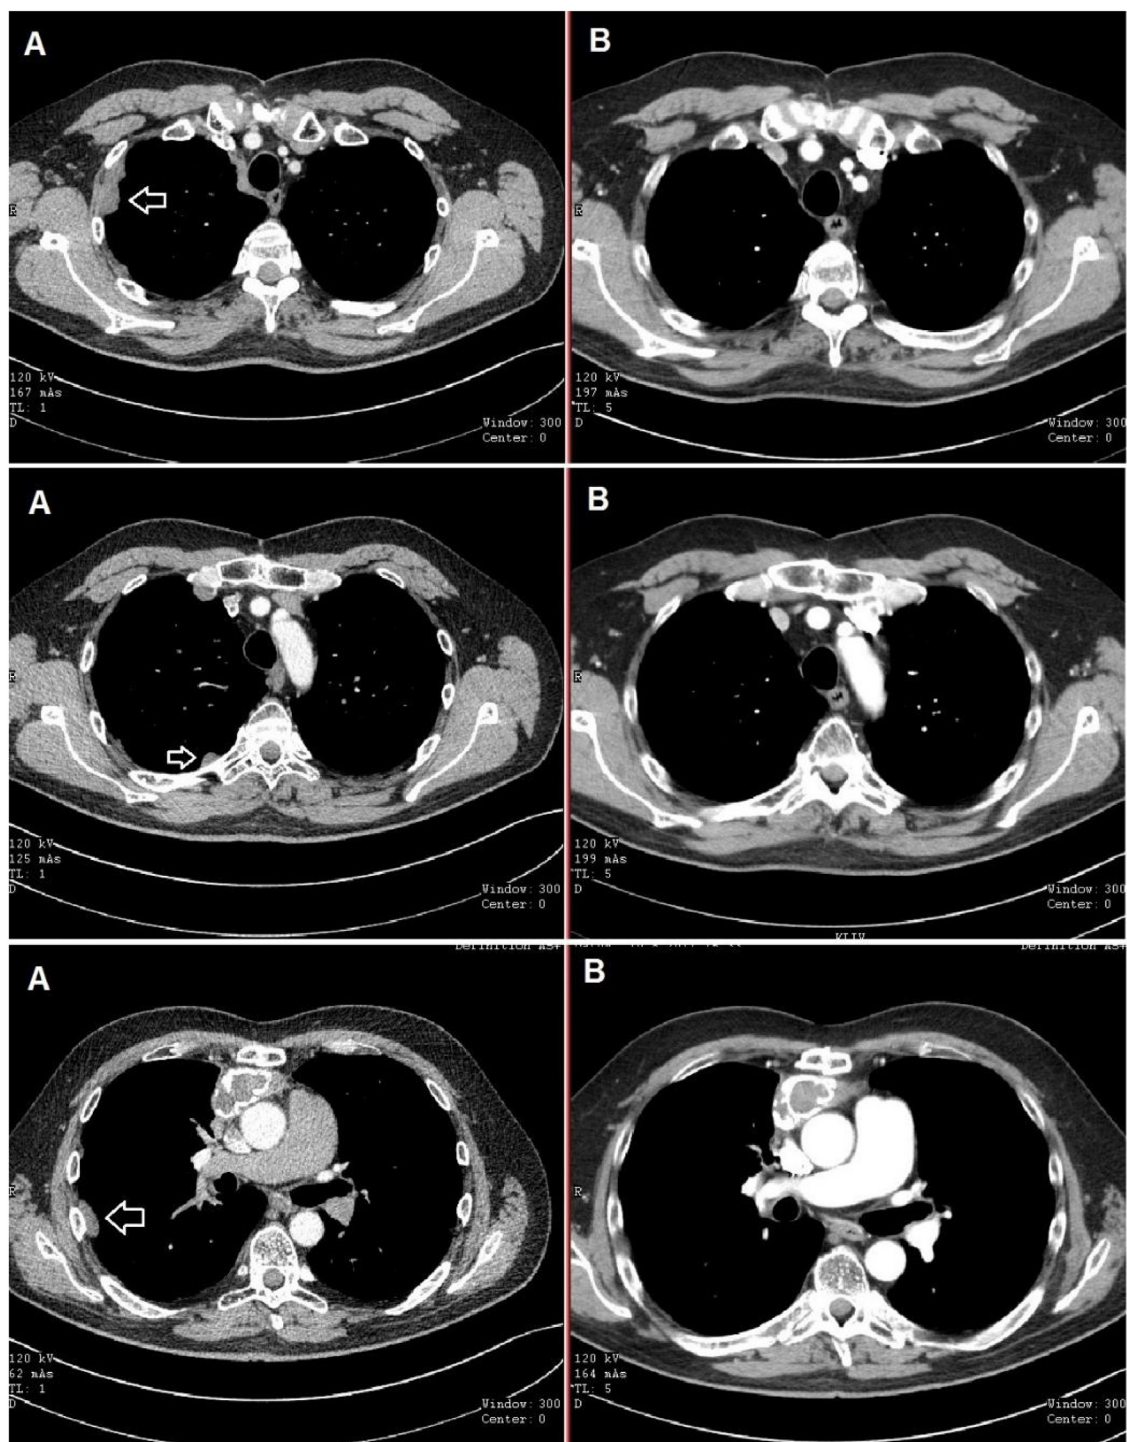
CT scans showing regression of multiple pleural masses (A: before octreotide treatment, B: after two months).
